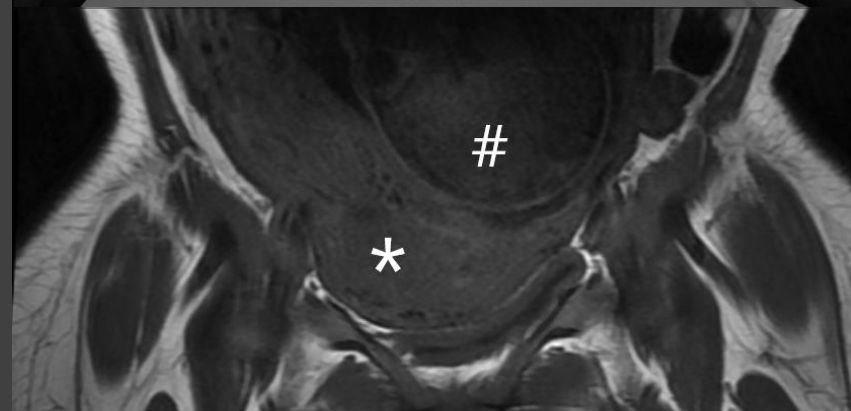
MRI pelvis at 32+2 weeks gestation demonstrating the fetal head (#) in relation to the large anterior fibroid (*)
